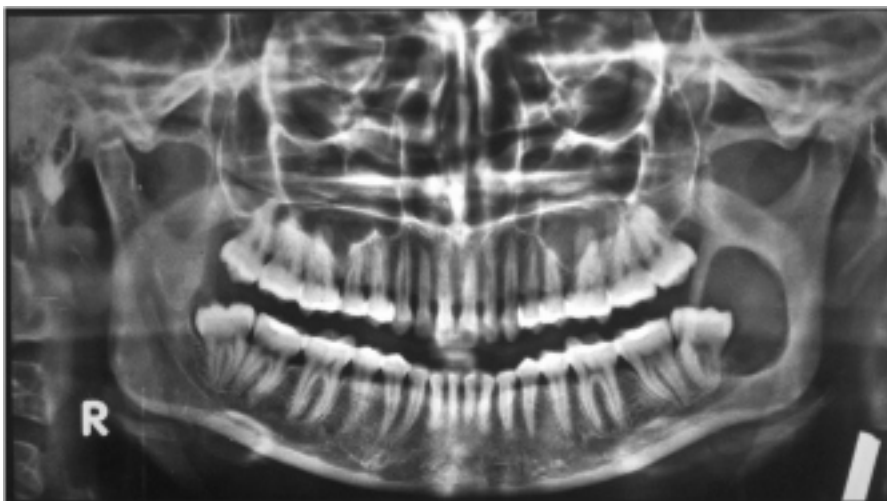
Panoramic Radiograph Shows Radiolucency Associated With Left Mandibular Third Molar Region.
